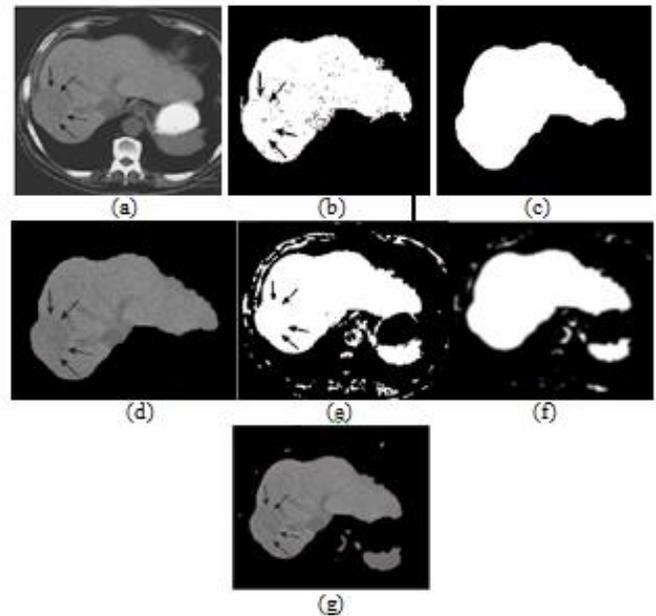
Semi-Automatic Liver Extraction from CT Images, a) Original Image, b) Region Growing, c) Morphological Function, d) Extract Liver, e) Median Filter Result, f) Morphological Function, g) Final Result of Liver.
